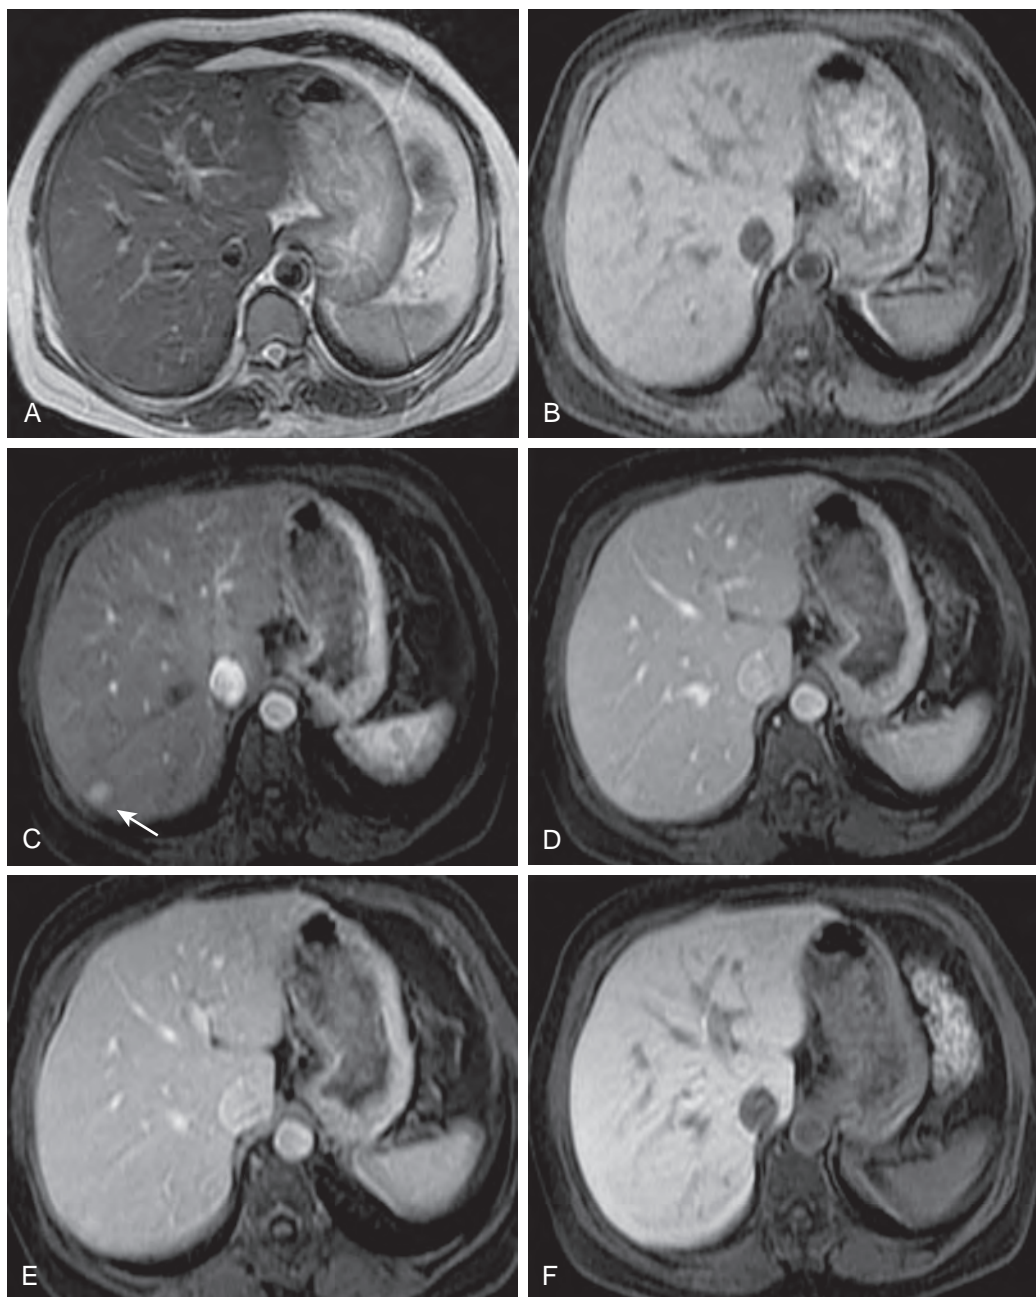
Focal nodular hyperplasia: MRI features. A small FNH in the right lobe of the liver. The lesion is isointense with the liver parenchyma on the T2- and T1-weighted images (A and B). It shows strong arterial enhancement and becomes visible on the arterial phase image (arrow, C). On the portal venous and hepatic venous phase images (D and E), FNH becomes isointense with the liver. Because it shows uptake of the hepatobiliary contrast agent, it remains isointense with the liver on the hepatocellular phase image (F).
